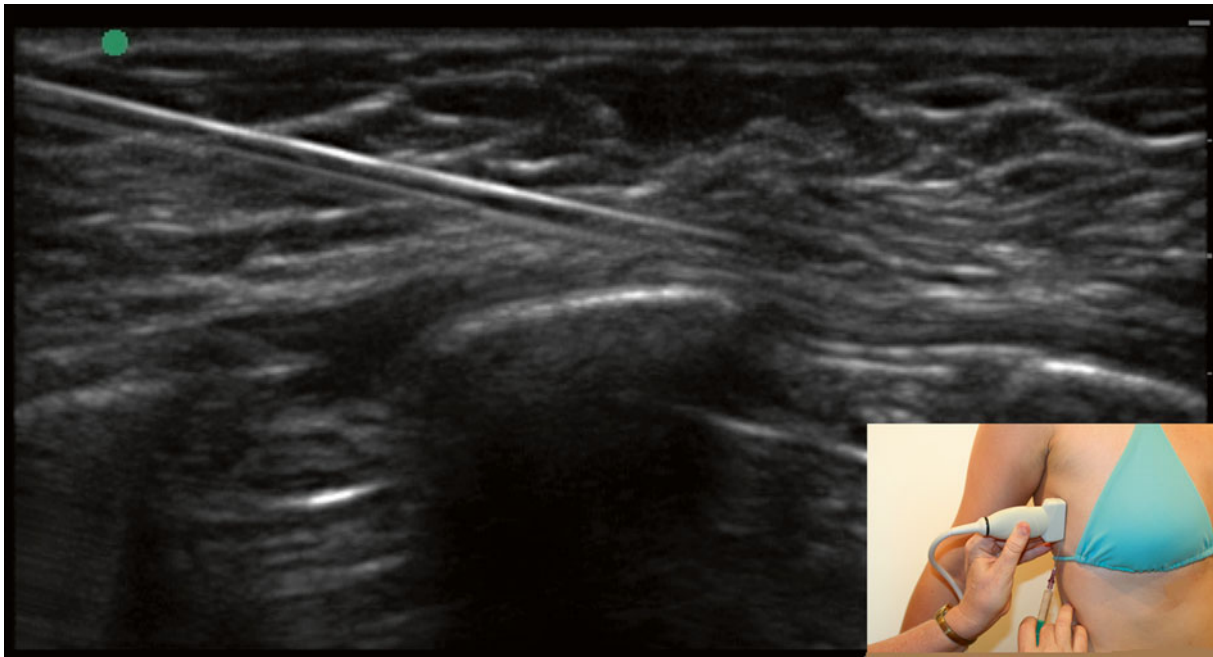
Ultrasound-guided injection of the long thoracic nerve at the axilla using an in-plane technique (Image courtesy of Andrea Trescot, MD)
